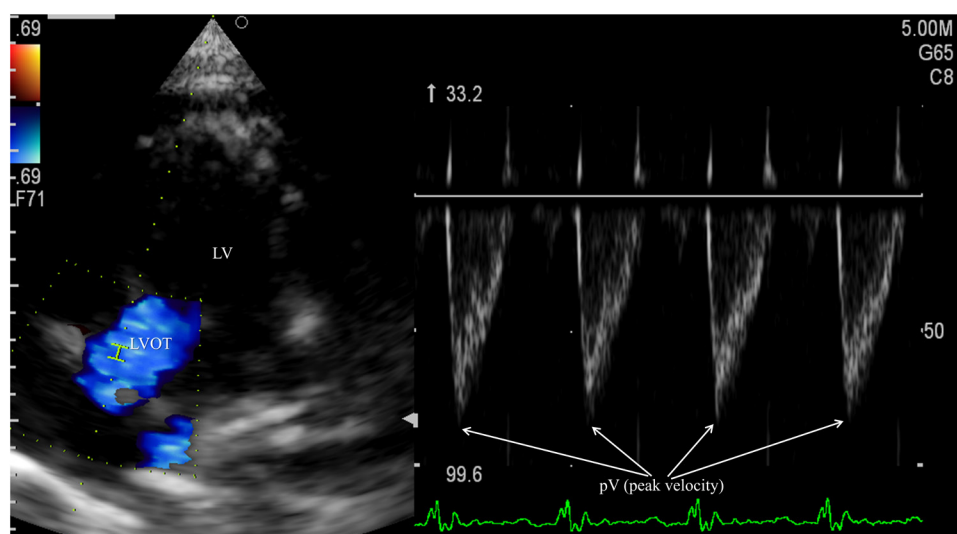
Showing parasternal long-axis apical 5-chamber view. The sample volume is placed at the aortic valve for measuring aortic Doppler velocity. LV = left ventricle; LVOT = left ventricular outflow tract.
